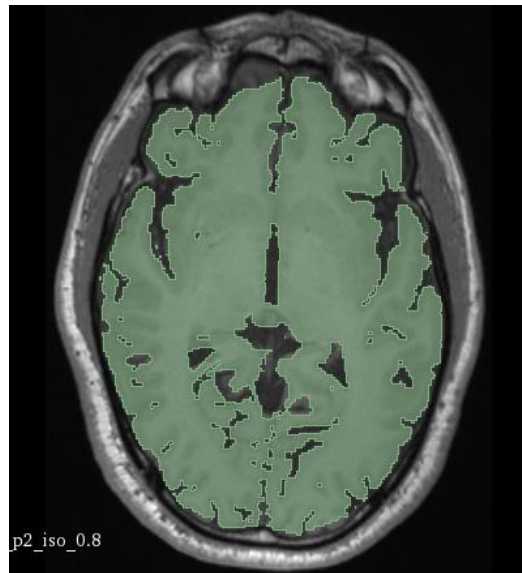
Refined MRI slice.
